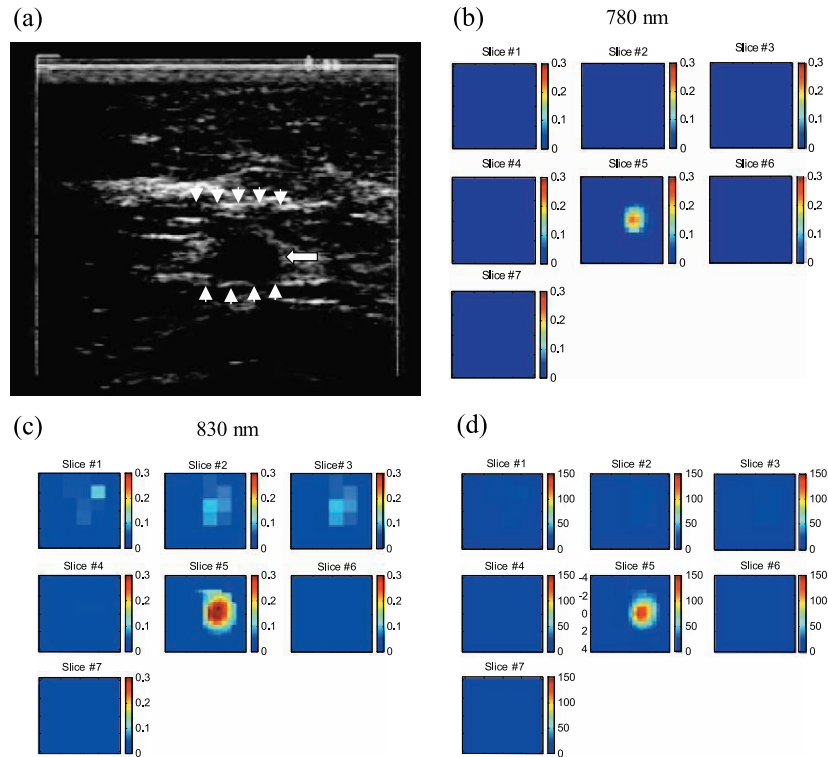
(a) shows a gray scale ultrasound image of a nonpalpable lesion of a 55-year-old woman. The lesion pointed by the arrow was located at the 4 o'clock position of the right breast measuring 8 mm in diameter. Ultrasound showed nodular mass with internal echoes and the lesion was considered suspicious. (b) and (c) are optical absorption maps at 780 and 830 nm, respectively. x and y axes are spatial dimensions of 9×9 cm. The slices starting from left to right correspond to absorption maps from 0.7 cm underneath the skin surface to the chest wall in 0.5-cm spacing. (d) is the total hemoglobin concentration and the vertical scale is in micromoles.
